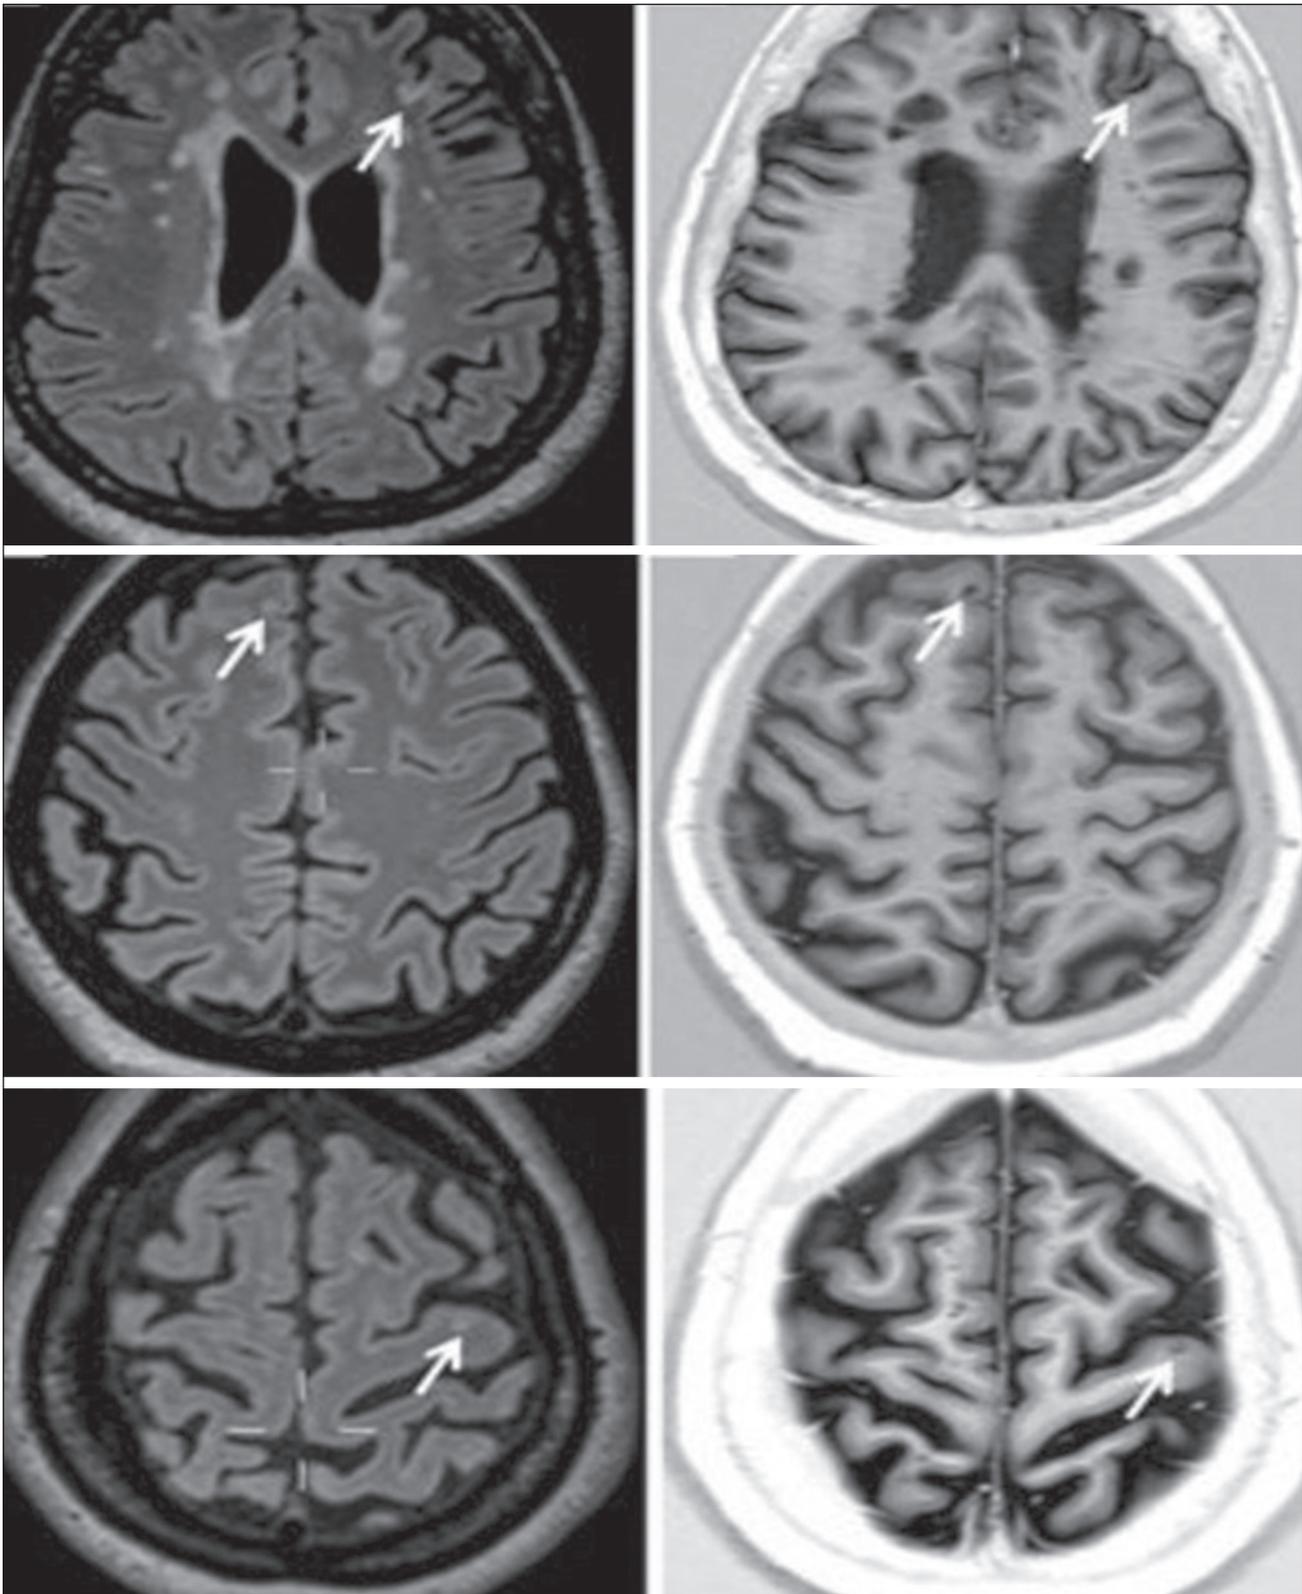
Axial 3D FLAIR (left) and axial PSIR (right): leukocortical (type I) lesion (top); juxtacortical lesion (middle); and intracortical (type II) lesion (bottom).
